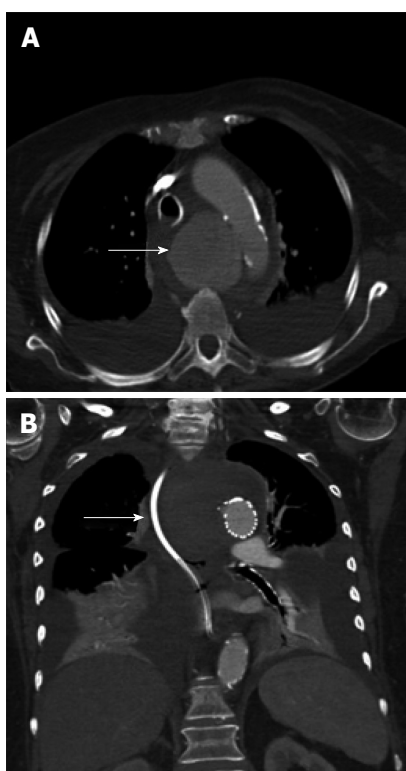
Computed tomography of the chest with intravenous contrast showed a saccular thoracic aortic aneurysm (5.0 cm × 5.0 cm) (arrow). Pre (A) and post (B) TEVAR with surrounding hematoma compressing the trachea, esophagus and superior vena cava. TEVAR: Thoracic endovascular aortic repair.
